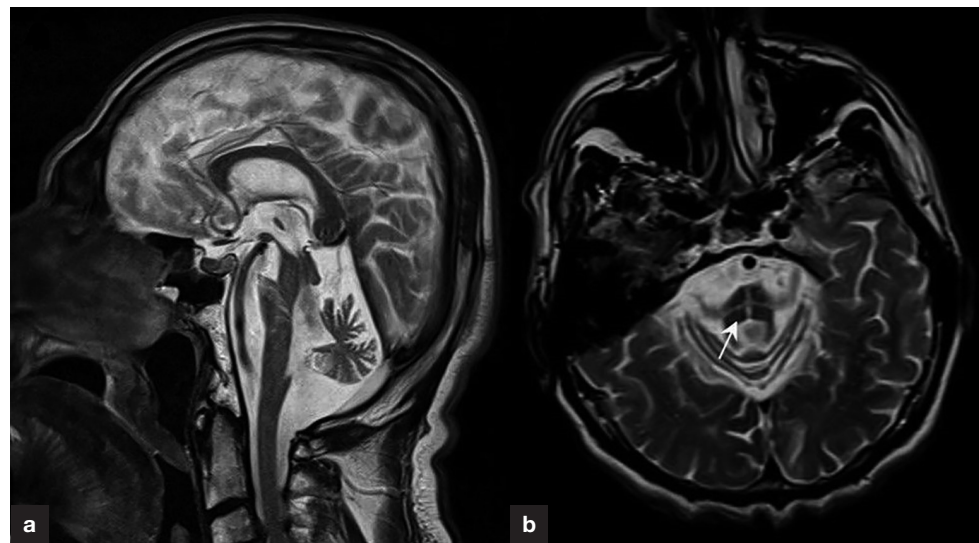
a. Sagittal T2-weighted imaging reveals atrophy of the brainstem and cerebellum. Atrophy appears to be more severe in the pons. b. A cruciform hot cross bun sign was detected in the pons on the axial T2-weighted sequence (arrow).
